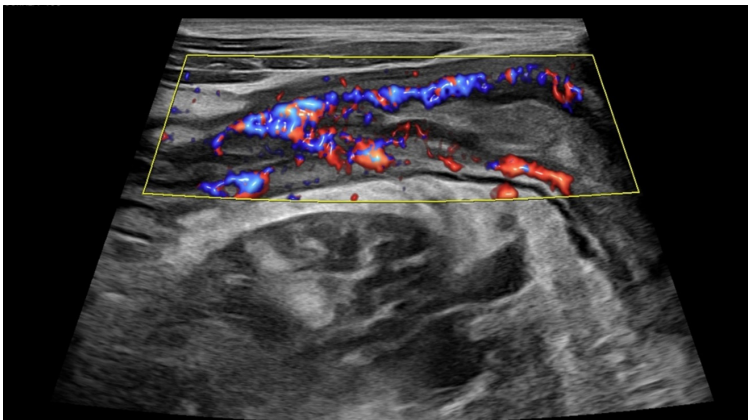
Increased focal vascularity shown in color doppler ultrasound.
